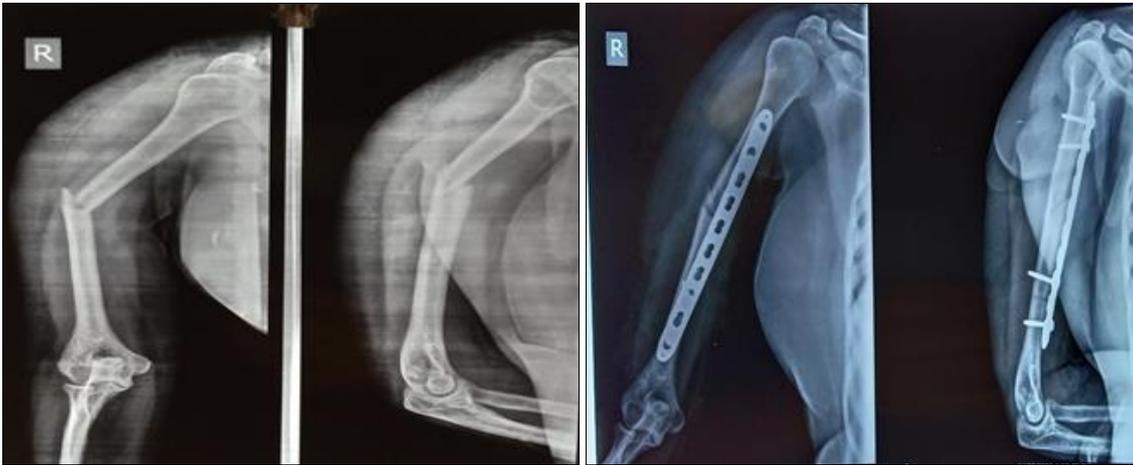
Pre-OP x-ray, Post-op x-ray of ABP plating
